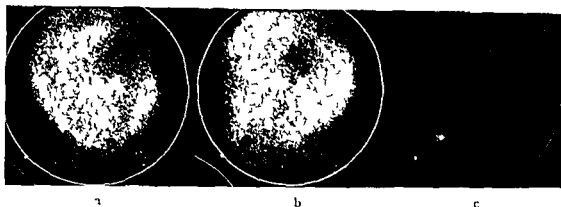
a) Anterior scintigram of a placenta obtained with a diverging collimator after injection of 1 mCi ^{125}I in m . A total of 100 000 counts has been accumulated. The marking in the film indicates the position of the uterine cervix. b) Lateral scintigram. c) The ^{67}Co marking point is indicated in the lateral scintigram. 2 000 counts in 10 s.
